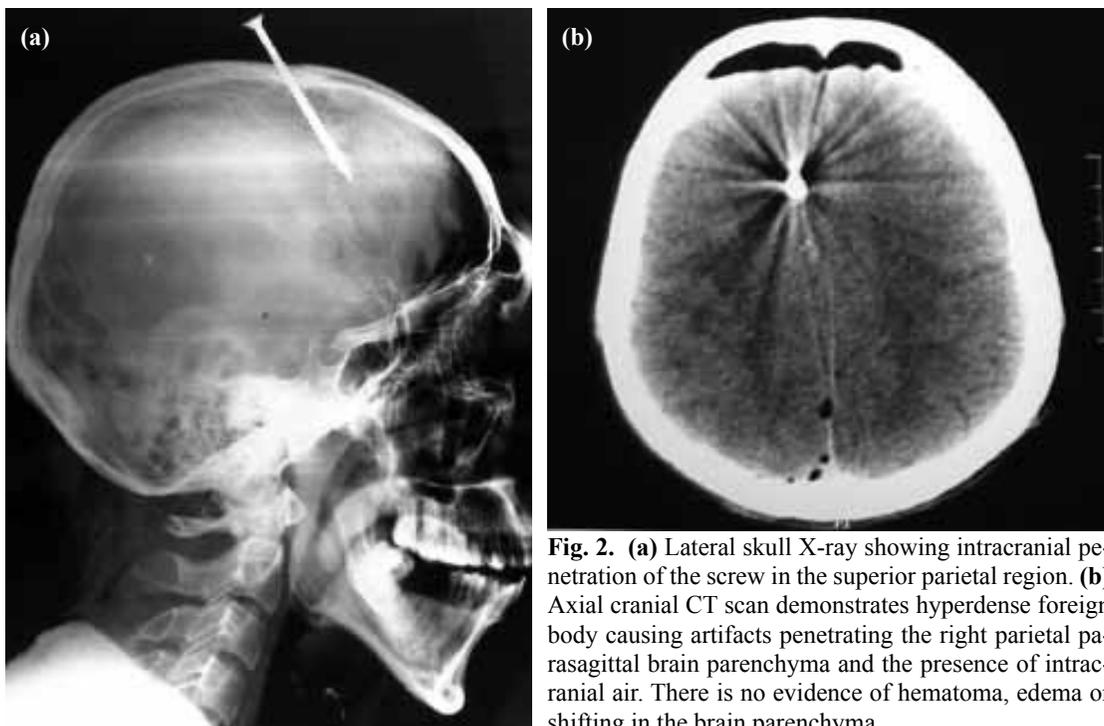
(a) Lateral skull X-ray showing intracranial penetration of the screw in the superior parietal region. (b) Axial cranial CT scan demonstrates hyperdense foreign body causing artifacts penetrating the right parietal parasagittal brain parenchyma and the presence of intracranial air. There is no evidence of hematoma, edema or shifting in the brain parenchyma.
